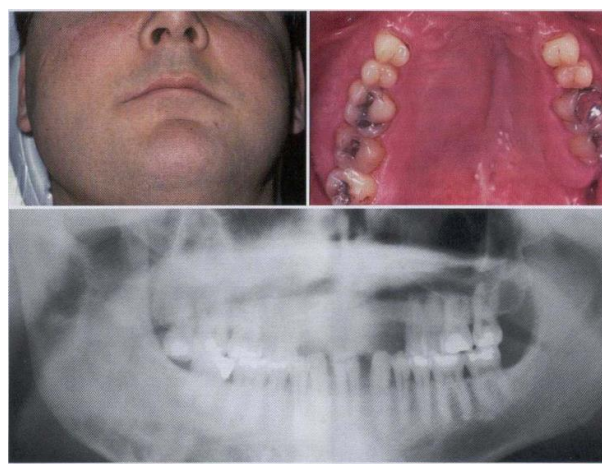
Young man exhibiting enlargement of the right maxilla and mandible; B intraoral photograph showing unilateral maxillary expansion; C. panoramic radiograph showing ill-define d lesions of the right side of both jaws
